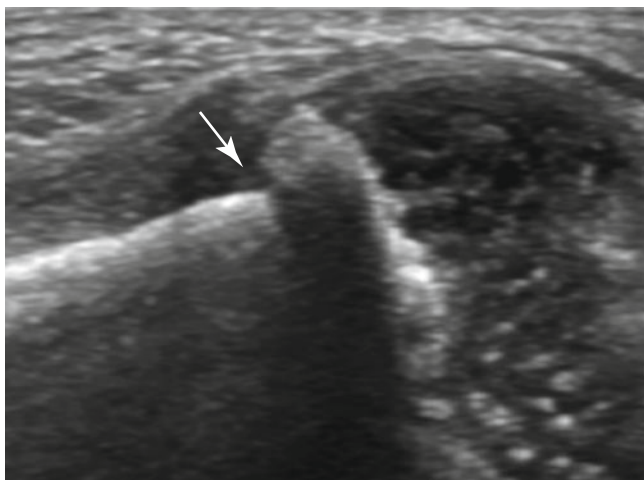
Buckle fracture in a newborn boy who presented with irritability. Ultrasonography of the right humerus shows buckle fracture at the junction of metaphyseal and diaphyseal bone (arrow). The more porous metaphyseal bone fails in compression
